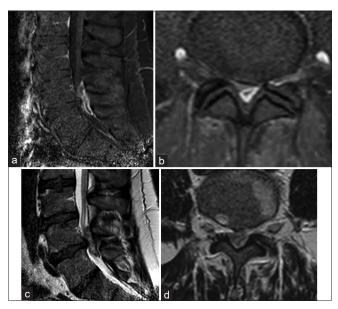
Lumbosacral spine MRI showed L4-L5 posterior extradural compression with peripheral contrast-enhancement on T1-weighted sagittal and axial sequences (a and b) and hypointensity on T2-weighted sagittal and axial sequences (c and d).
